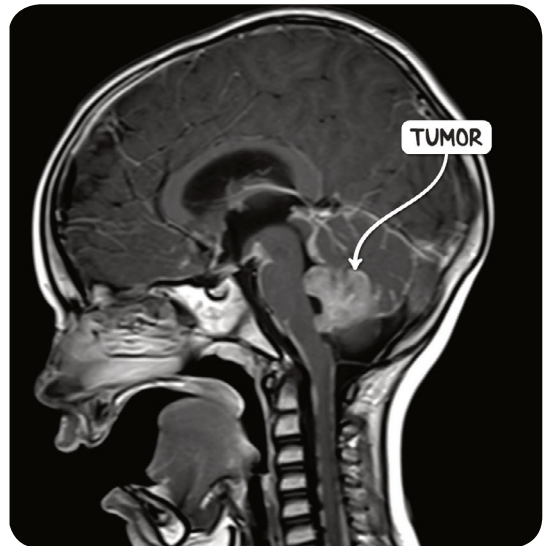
An MRI scan of a child in the sagittal plane demonstrating a medulloblastoma. In childhood, they commonly arise in the posterior fossa at the roof of the fourth ventricle.
